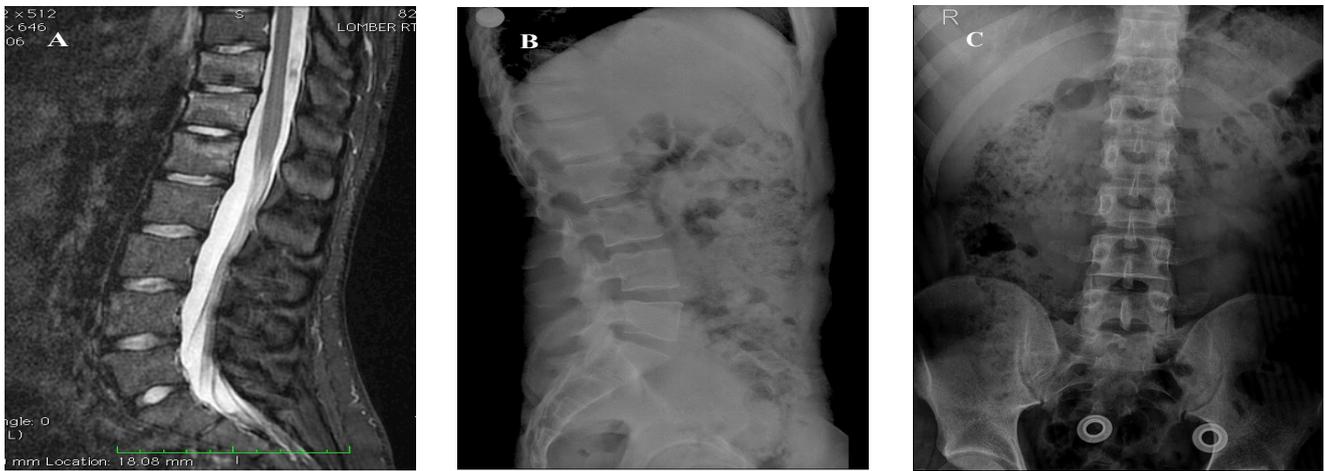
The MRI of a patient who had type A fractures of T11-12 and L1 (A) and radiographic images with TLSO corset (B, C).
